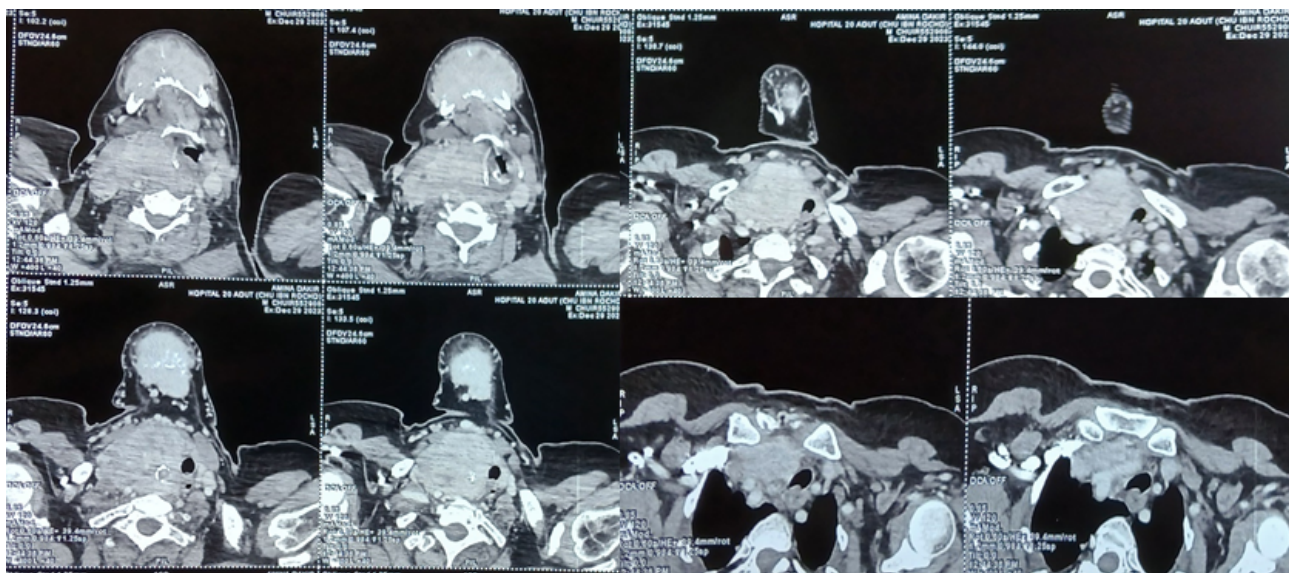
CT-Scan revealing a giant anterior mandibular mass along with multinodular goiter
